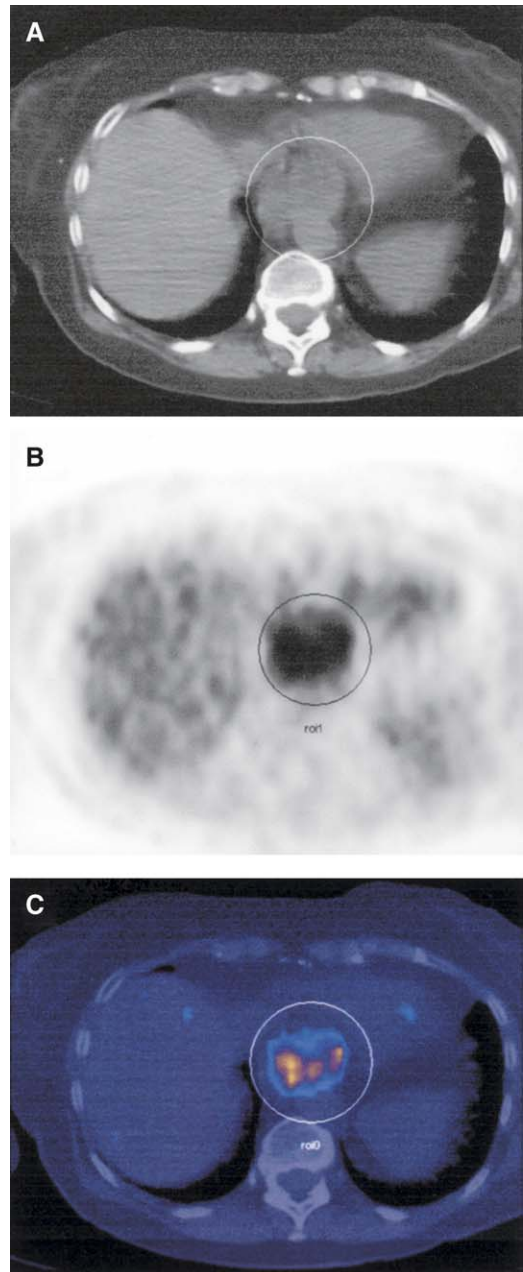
CT/PET fusion study depicting esophageal carcinoma in the distal third of the esophagus. The lesion is encircled in each panel. (A) Noncontrast CT image. (B) FDG-PET image. (C) CT/PET fusion image.
